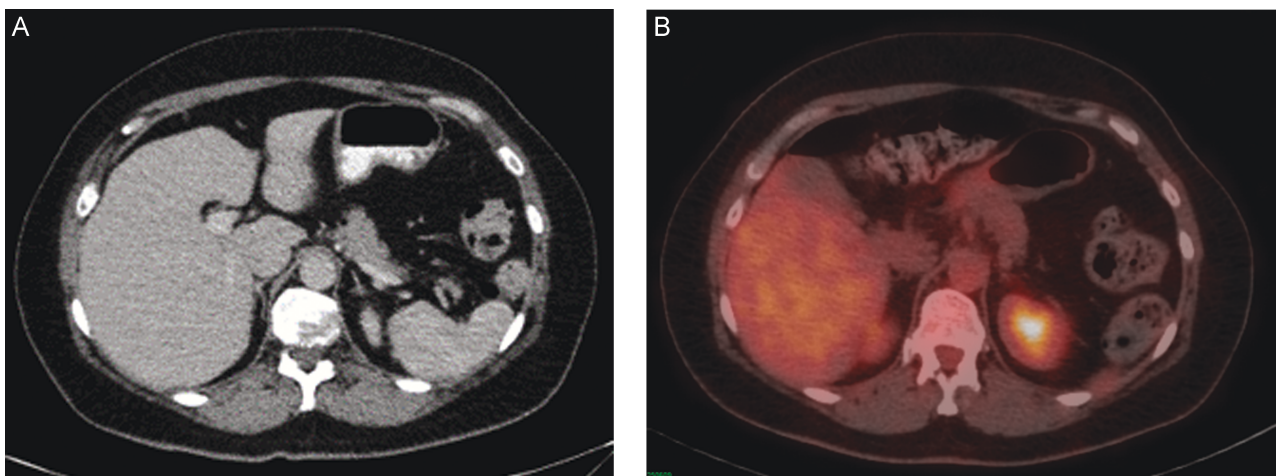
A and B: Case 1 PET-CT images of the adrenal glands.
